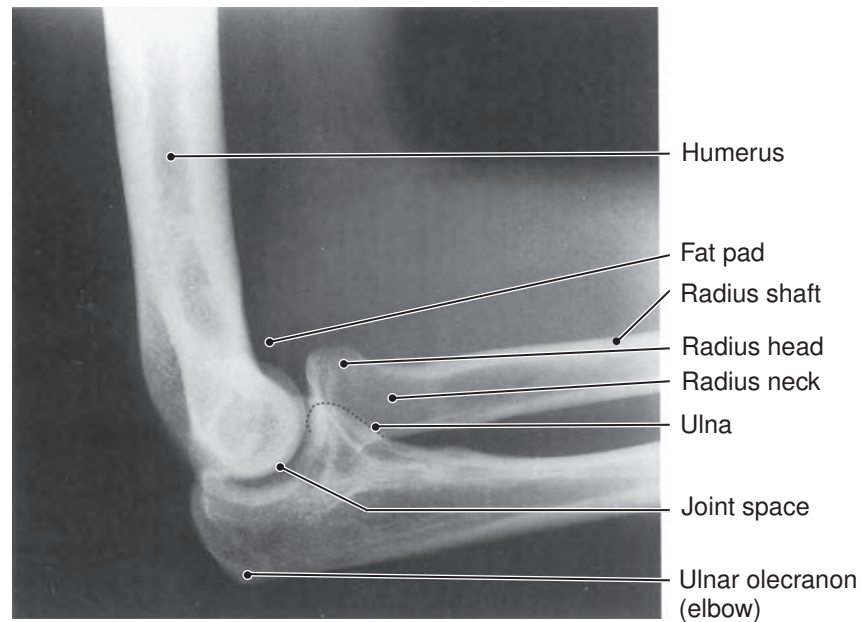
Radiograph of a normal left elbow joint, lateral view. The olecranon (*ō-LEK-ra-non*) is the proximal ulnar enlargement that forms the prominent bone of the elbow.
